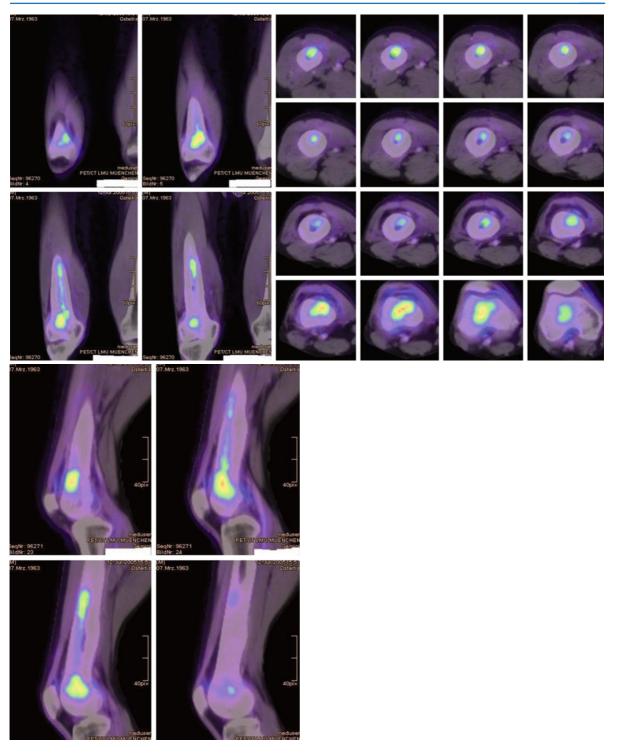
Chronic osteitis: image of right femur with FDG PET CT
